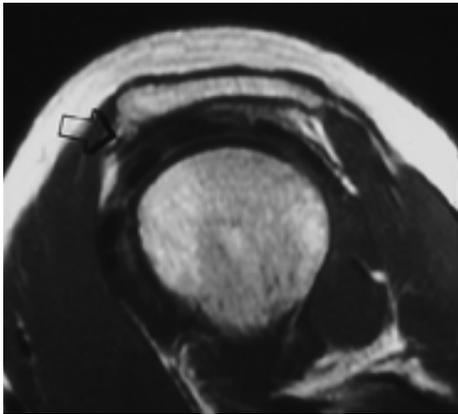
Oblique sagittal MR image in a 51-year-old woman demonstrated curved shape of acromion with subacromial spur(arrow). This slice is obtained just lateral to the acromioclavicular joint.
